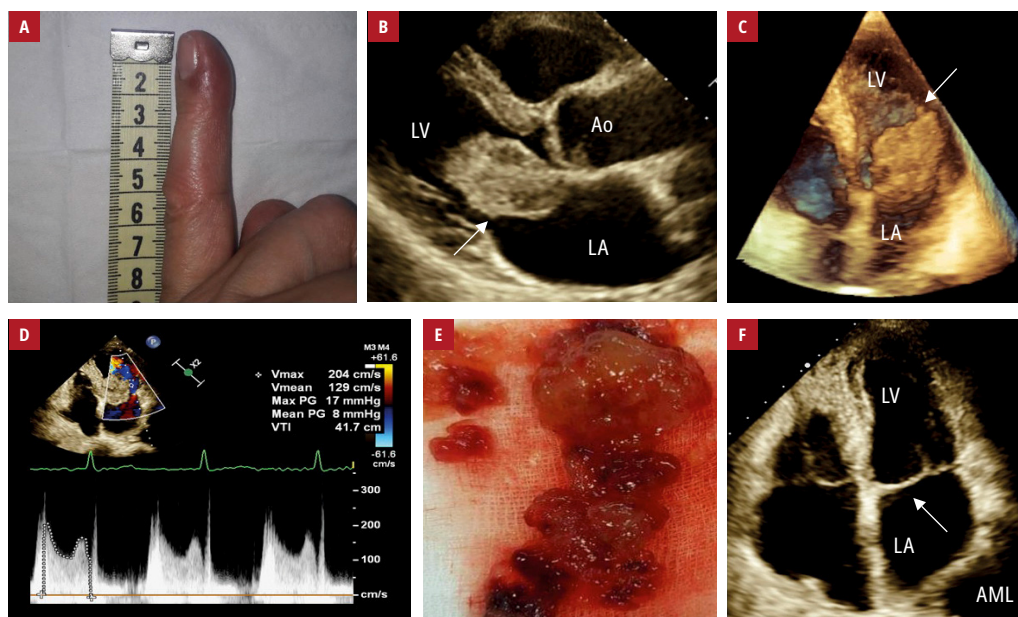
A – swelling and redness of the index fingertip; B – transthoracic echocardiography (TTE), long-axis view: a pathological mass possibly attached to the anterior mitral leaflet, prolapsing into the left ventricle during diastole (arrow); C – 3-dimensional TTE, 4-chamber view: a small, mobile structure on the tumor surface (arrow); D – Doppler measurements indicating functional mitral valve stenosis; E – a fragile myxomatous mass removed from the left atrium; F – follow-up TTE performed 3 months after the surgery, 4-chamber view: normal mitral valve morphology (arrow)
